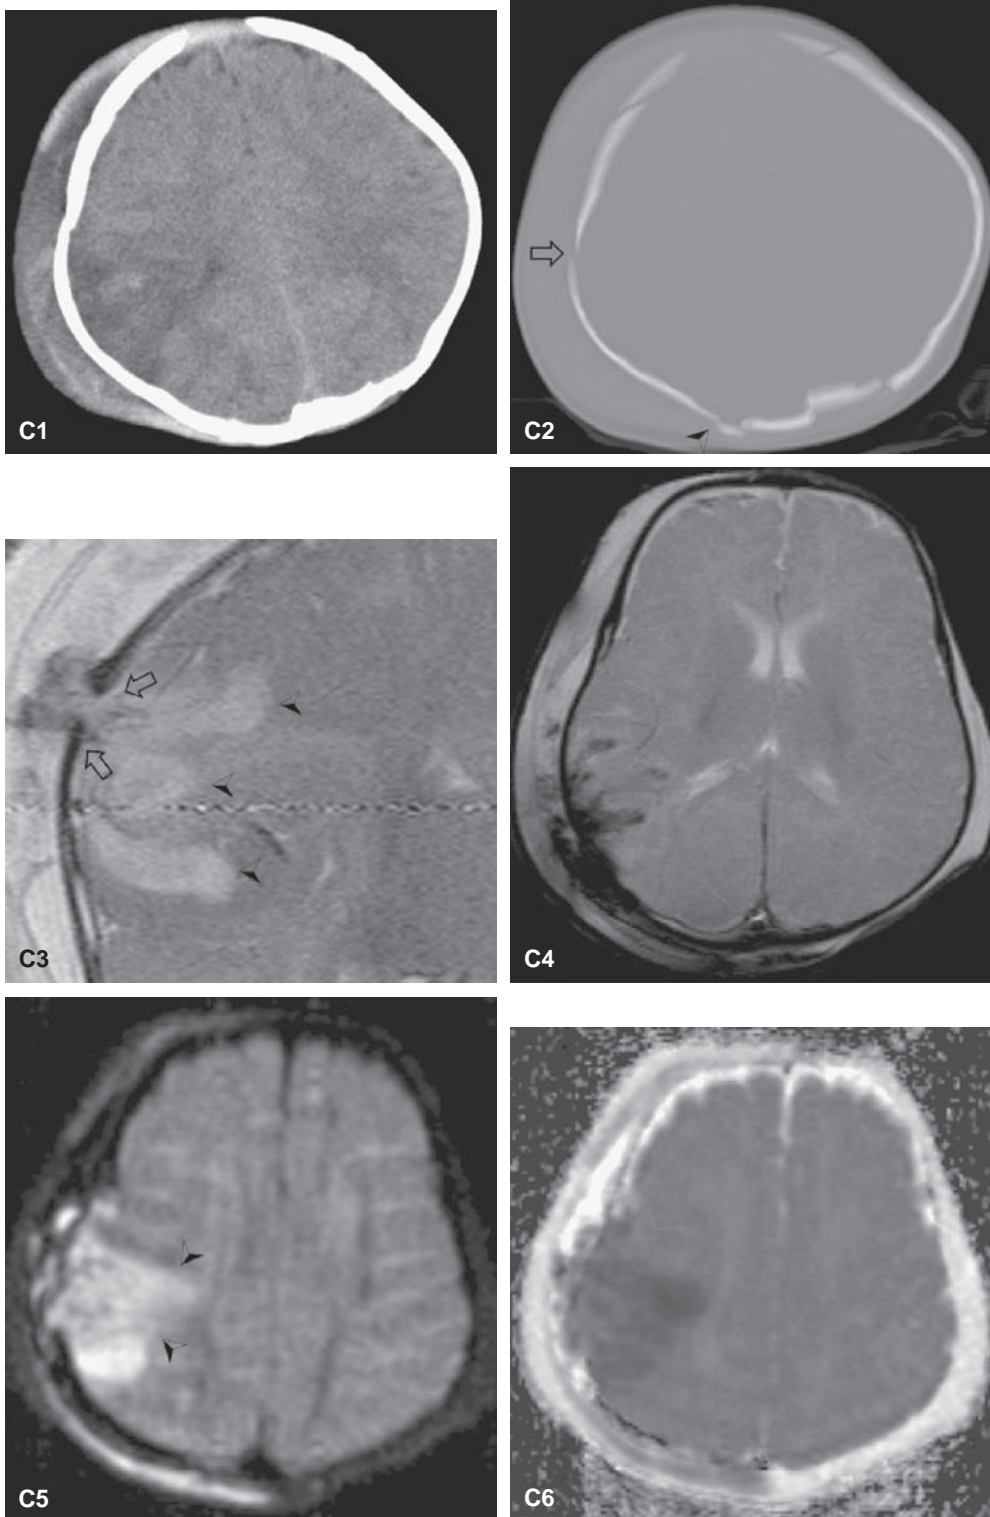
(Continued) C: Five-month-old male infant examined by CT and MRI on the day of admission. Parts C1 and C2, axial CTs without contrast; parts C3–C6, MRI images. C1: Axial CT, brain windows, shows hemorrhage within the soft tissues of the scalp; underlying hypodensity and hyperdensity within the brain in the right parietal region consistent with contusional change. C2: Axial bone window at the same level as C1 shows a fracture of the right parietal bone (*arrow*) and an additional area of fracture posteriorly at the lambdoid suture (*arrowhead*). C3: Coronal T2WI demonstrates separation of the bone at the site of fracture (*arrow*) and underlying brain swelling involving the cortex, consistent with contusion (*arrowheads*). Abnormality is present at the site of the fracture in the extracalvarial soft tissues, consistent with hemorrhage and/or herniation of brain tissue through the fracture. C4: Axial two-dimensional FLASH susceptibility gradient echo scan demonstrates extensive intraparenchymal and soft-tissue scalp areas of signal loss consistent with bleeding. C5: Axial diffusion imaging through the site of contusion shows restricted motion of water consistent with cytotoxic edema (*arrowheads*). C6: Axial apparent diffusion coefficient (ADC) map at the site of the restricted motion of water shows hypointensity consistent with cytotoxic edema. (Courtesy of Robert A. Zimmerman, MD.) (*continued*)
